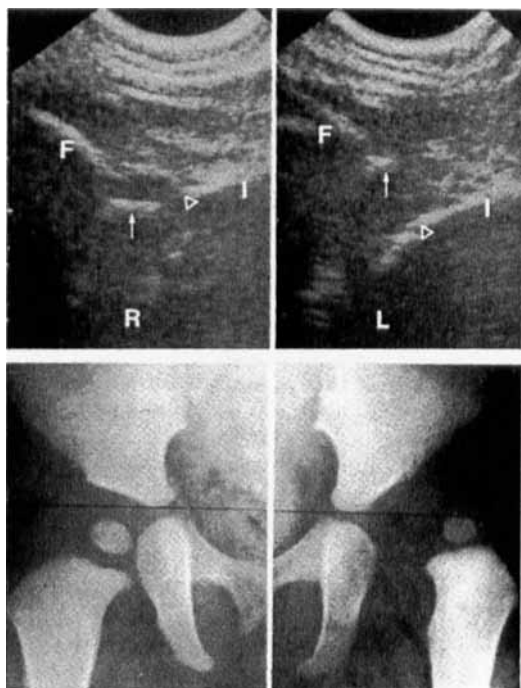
Ultrasound pictures and radiograph of dislocation of the left hip (L) in a girl aged 9 months. F femur, I os ilium; other labels as in Figure 2. The femoral head is laterally and proximally dislocated, and there are bony defects of the lateral acetabular rim. The right hip (R) is normal.
